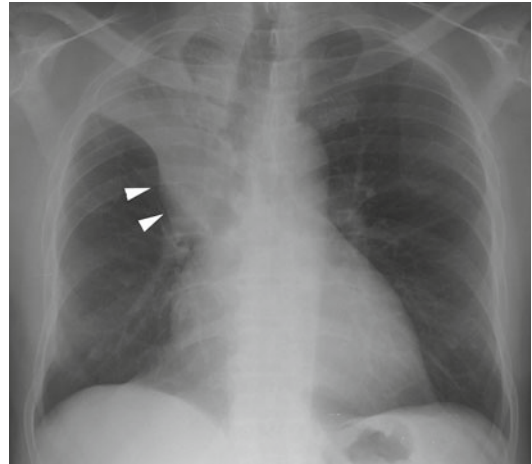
Frontal chest radiograph reveals central right hilar mass (*arrowheads*) resulting in collapse of right upper lobe (also known as “S” sign of Golden)
